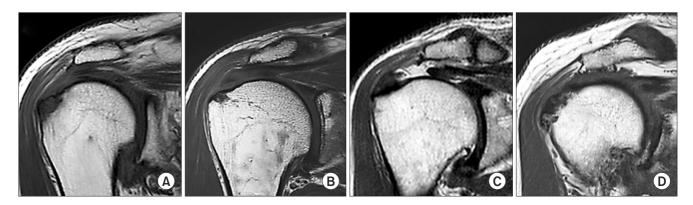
Types of acromial spurs as categorized in oblique coronal plane magnetic resonance images. (A) Normal acromion. (B) Lateral traction spur. The lateral acromial spur is congruent with the acromial undersurface. (C) Lateral bird beak type spur. The lateral acromial spur is incongruent with the acromial undersurface. (D) Heel type spur. The shape of the spur (inferior protrusion) looks like the heel of a shoe.
